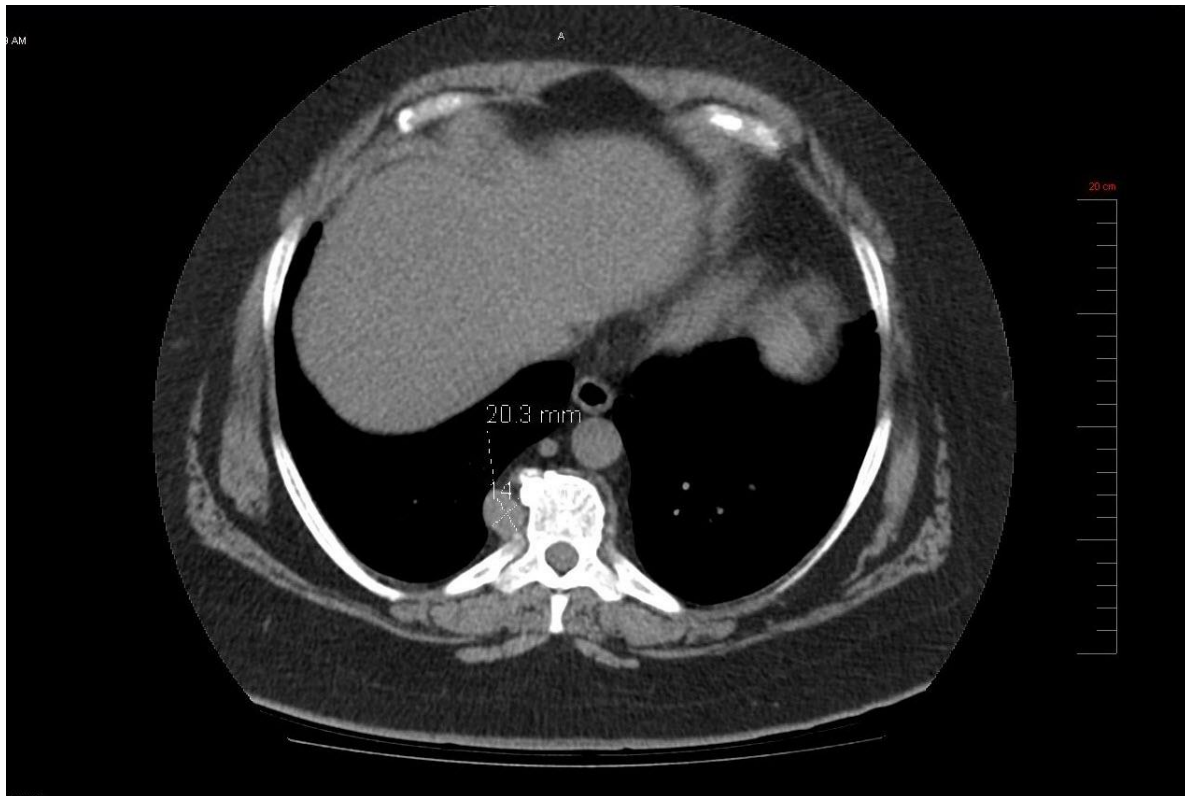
Right paravertebral mass, computed tomography scan.
